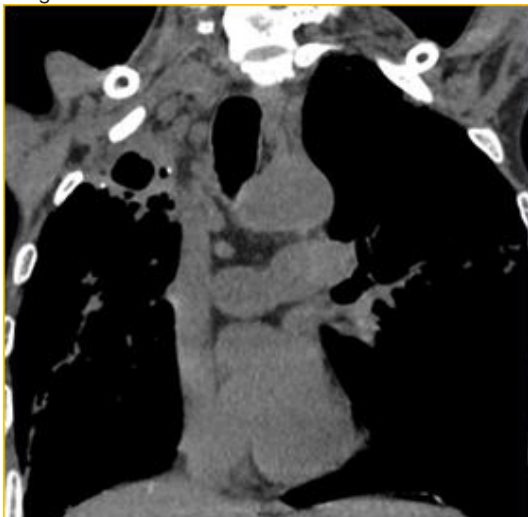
CT thorax mediastinal window in Coronal view
